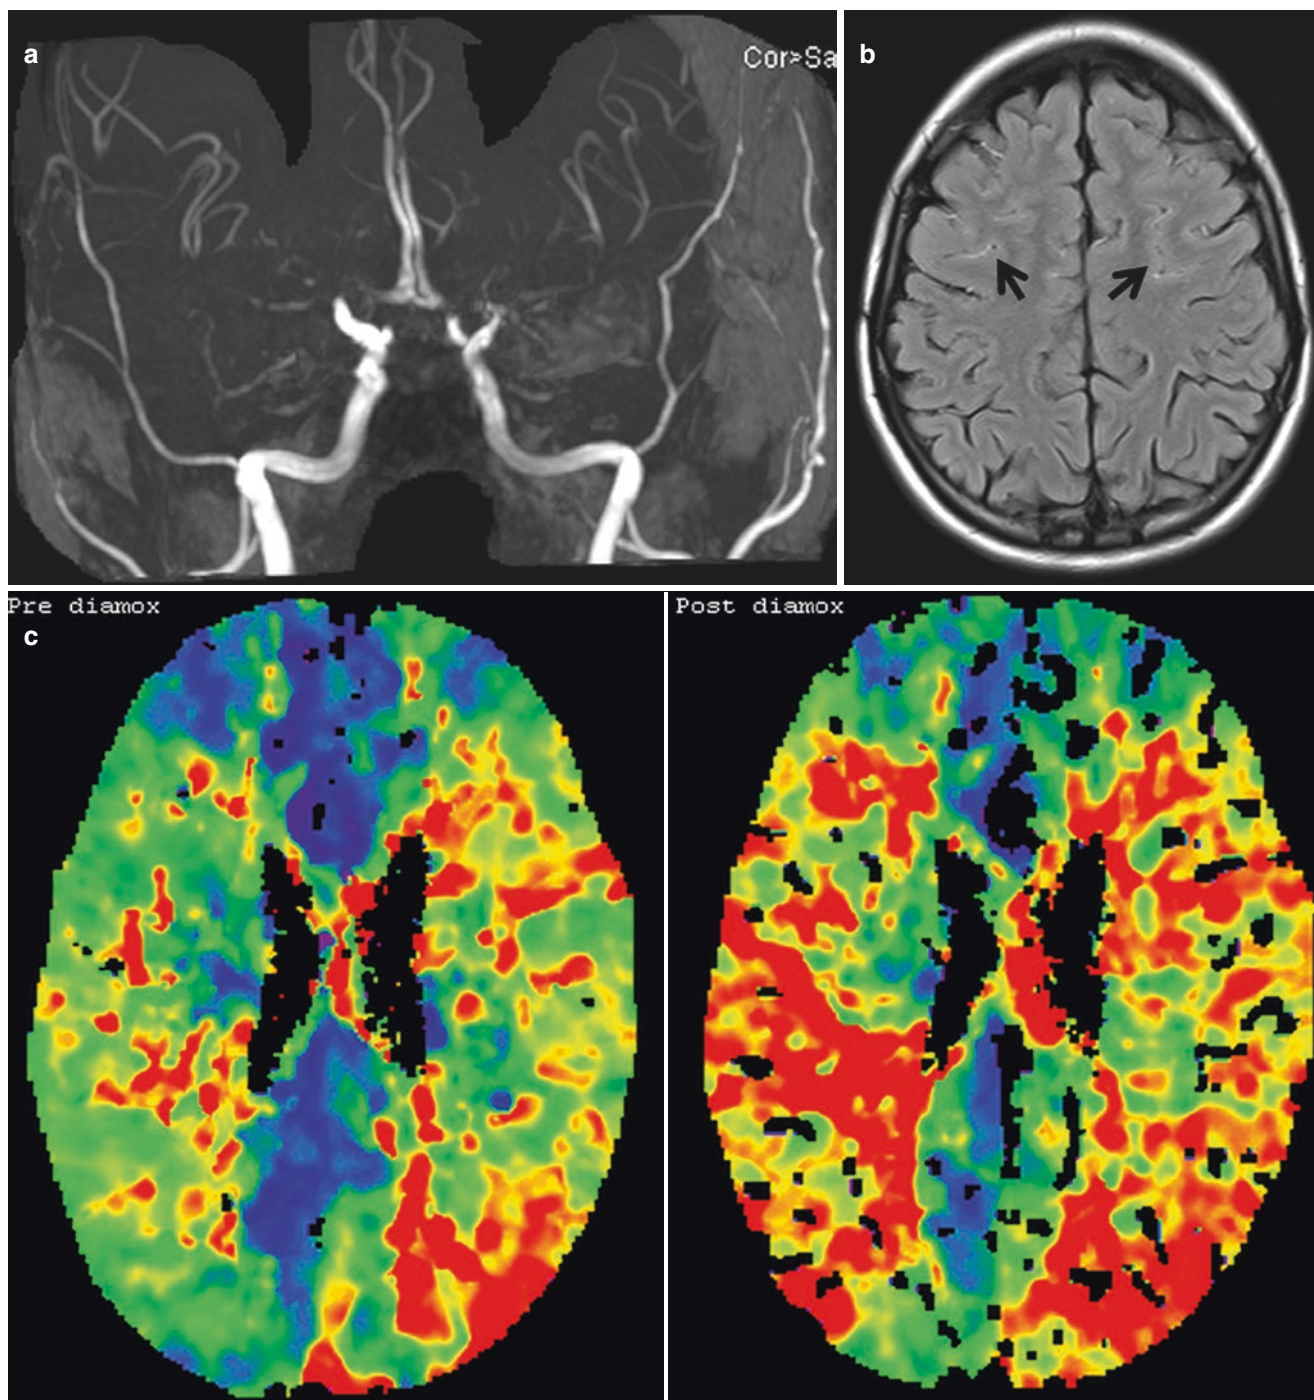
Moyamoya vasculopathy. A 15-year-old with transient right-sided weakness. (a) 3D TOF MRA shows occlusion of bilateral ICA termini and M1 and A1 segments, consistent with moyamoya vasculopathy. (b) MRI FLAIR image shows hyperintense signals within the cortical sulci (arrows) representing leptomeningeal collaterals (ivy
